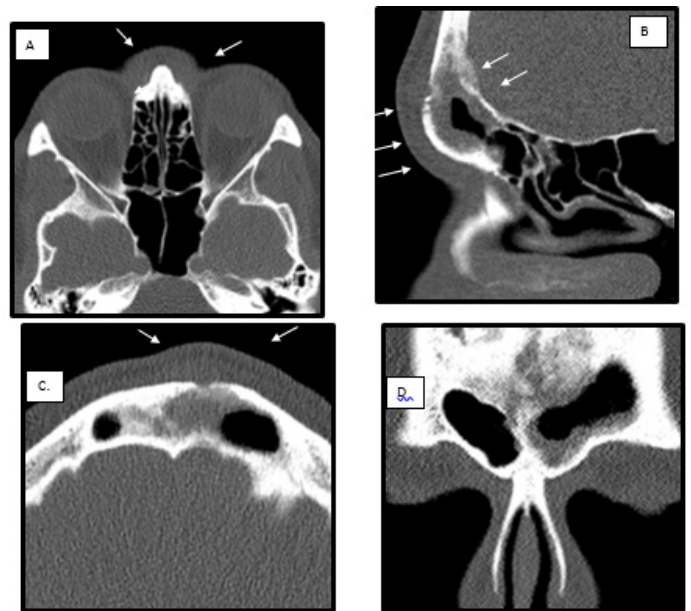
Computed tomography showing on cut A & C a swelling of the forehead and in front of the nasal bones. Cut B shows area of osteomyelitis in the anterior and posterior walls of the frontal sinus. Cut D shows a partial opacity of the left frontal sinus.
